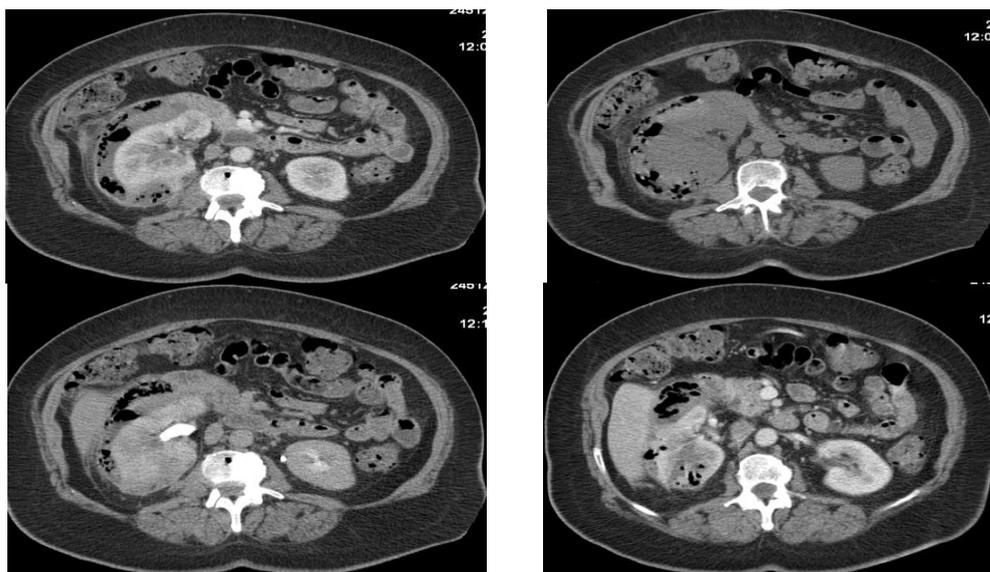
abdominopelvic* CT scan (native T1, native T2, after contrast medium injection, 10 minutes from contrast medium administration).
